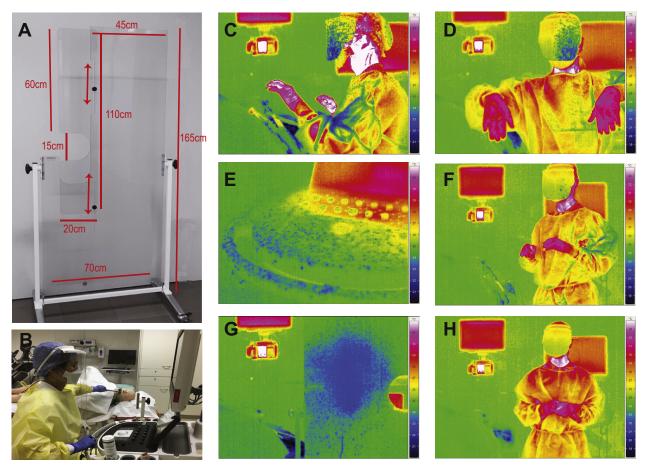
(A) Construction plan of the protective shield used for TEE. (B) Experimental setup. (C) Using infrared detection, water droplets are depicted as blue spots. Performing TEE while sitting, droplets are detected on the lateral side of the face shield, mask, cap, and left forearm. (D) The left side of the examiner, which faced the patient, is extensively contaminated. (E) The surface of the ultrasound machine is also contaminated. (F) Performing TEE in a standing position reduces potential contamination of the head. Droplets were found only on the left arm and the gloves. (G, H) When placing the protective shield between the mannequin and the examiner, droplets were blocked by the shield. Contamination was found only on the left forearm, which was placed in front of the shield.
